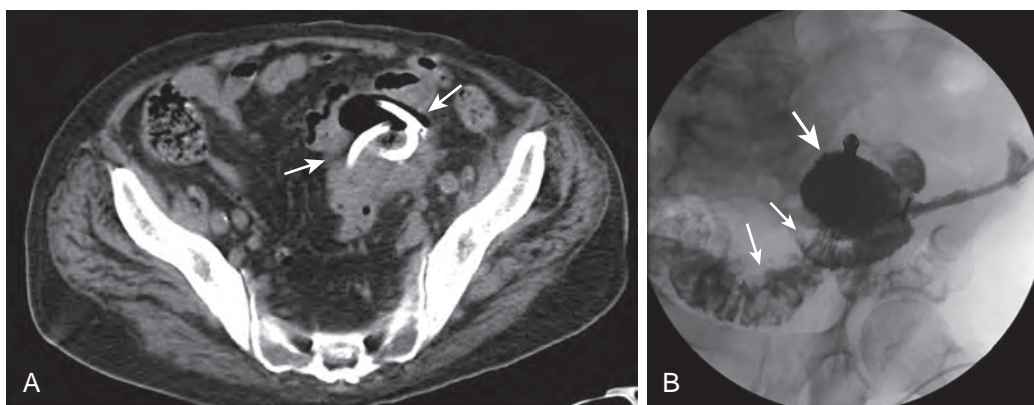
Diverticular abscess with fistulous communication to sigmoid colon. A. Axial CT image shows a percutaneous drainage catheter within a diverticular abscess associated with sigmoid diverticulitis (arrows). The patient continued to have persistent drainage from the catheter for 4 weeks. B. Fluoroscopically guided injection of contrast material into the abscess cavity (thick arrow) showed fistulous communication of the abscess cavity with the sigmoid colon (thin arrows).
